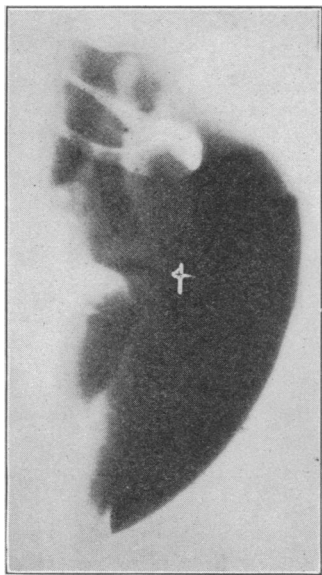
Lateral x-ray film of the normal larynx. Cross (x) indicates site of ventricles.
